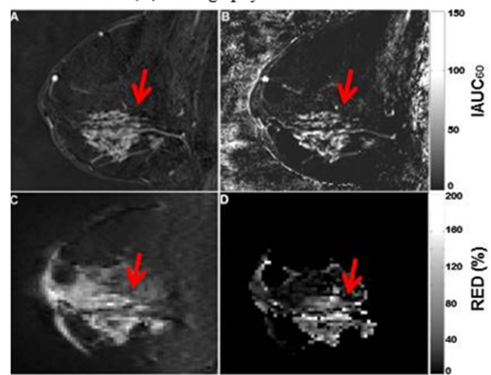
Invasive ductal carcinoma (red arrow). (A): DCE-MRI 2 minutes post-contrast subtracted image. (B): IAUC₆₀ parametric map. (C): DWI b=700 s/mm² image. (D): RED parametric map after filtering out low signal in DWI.
